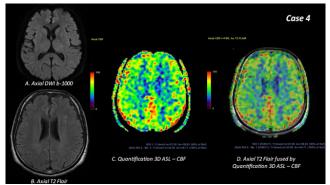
Male, 59 years old, suspect stroke; (A) Axial DWI b-value 1000; (B) Axial T2 Flair; (C) Quantification 3D ASL – CBF; (D) Axial T2 Flair fused by Quantification 3D ASL – CBF
